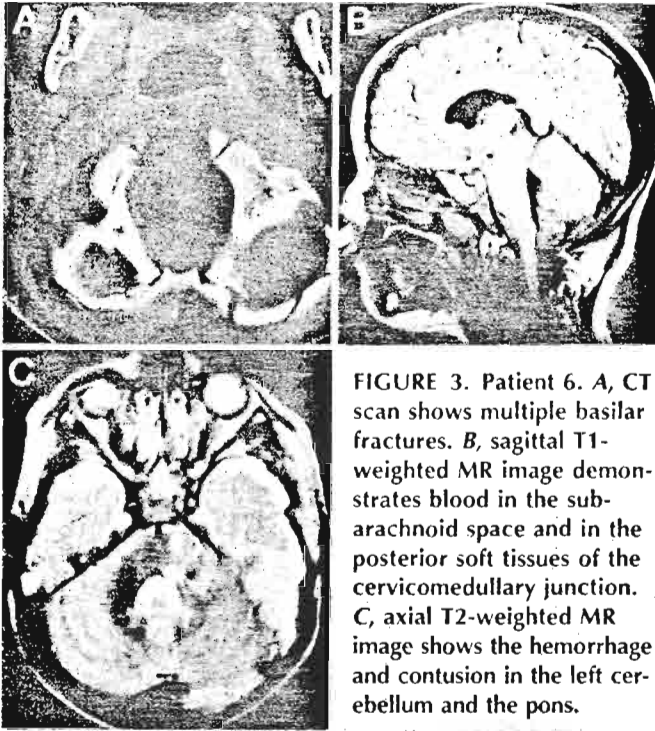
Patient 6. A, CT scan shows multiple basilar fractures. B, sagittal T1-weighted MR image demonstrates blood in the subarachnoid space and in the posterior soft tissues of the cervicomedullary junction. C, axial T2-weighted MR image shows the hemorrhage and contusion in the left cerebellum and the pons.
